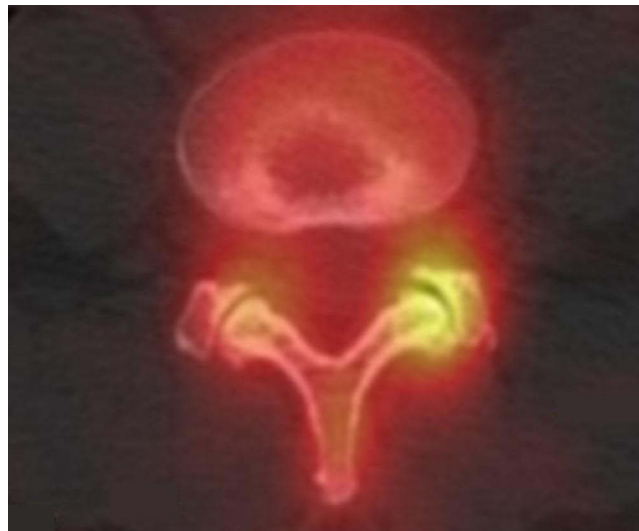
The bone single-photon emission computed tomography imaging findings of a 56-year-old woman with lumbar facet joint-origin lower back pain. Increased radiotracer uptake was observed in the left L4-L5 facet.
